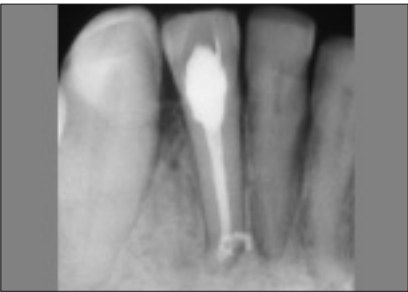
Radiograph taken 7 months after treatment shows improvement of the apical bone. The apical accessory canals and their portals of exit are filled. A previous radiograph showed that the main apical canal had been blocked.
